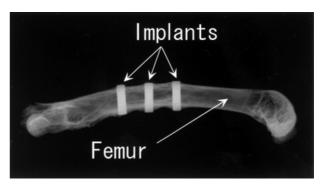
Soft X-ray image of the femur and implants (12 months after implantation).
